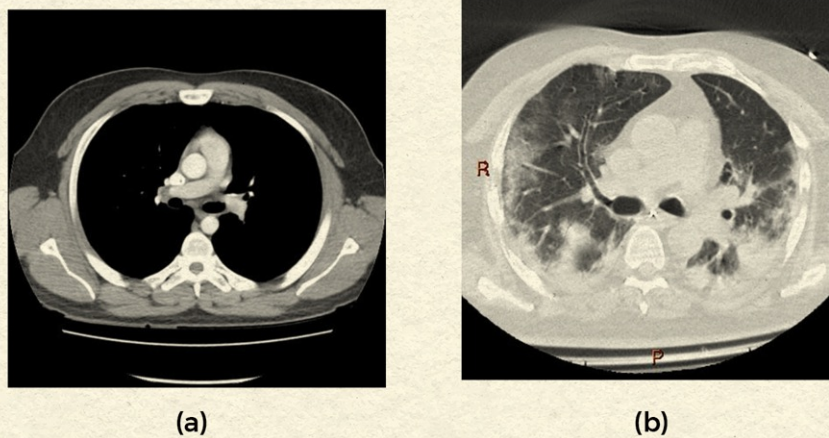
CT Thorax Result
